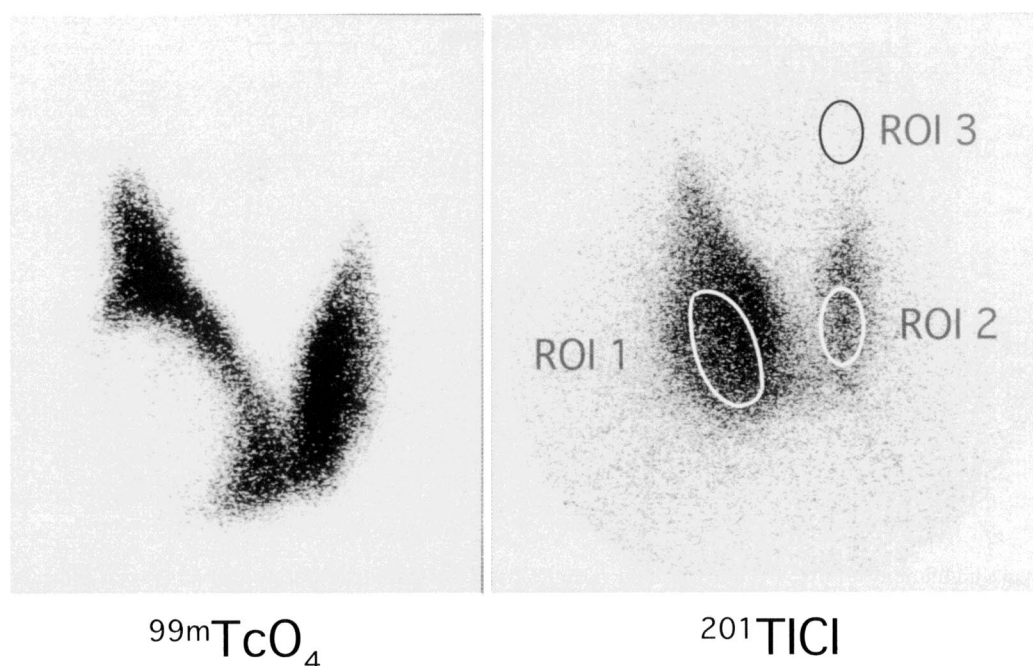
Based on $^{99m}\text{TcO}_4$ scintigrams of the thyroid, 3 regions of interest (ROI) were assigned: the neoplasm (ROI 1), the contralateral lobe of the thyroid (ROI 2), and the sternocleidomastoid muscle sufficiently apart from the thyroid gland (ROI 3).
